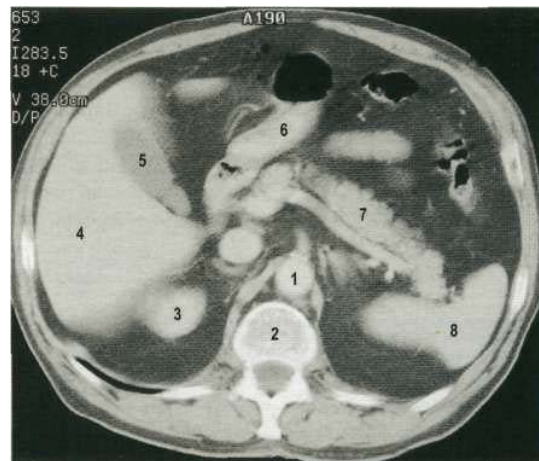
CT scan of the normal abdomen at the level of T12. 1, aorta; 2, spine; 3, top of right kidney; 4, liver; 5, gall bladder; 6, stomach (containing air); 7, pancreas; 8, spleen.
